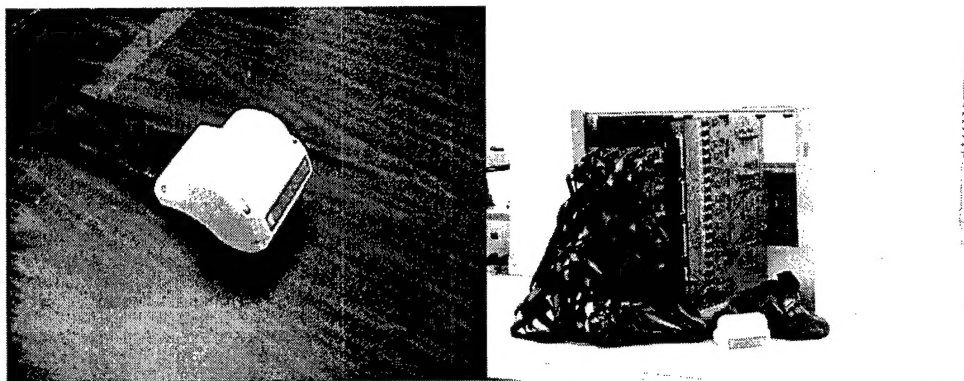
(a) The state-of-the-art 1.75-D ultrasound array made by Tetrad Inc. (b) Data acquisition system build by our group.
